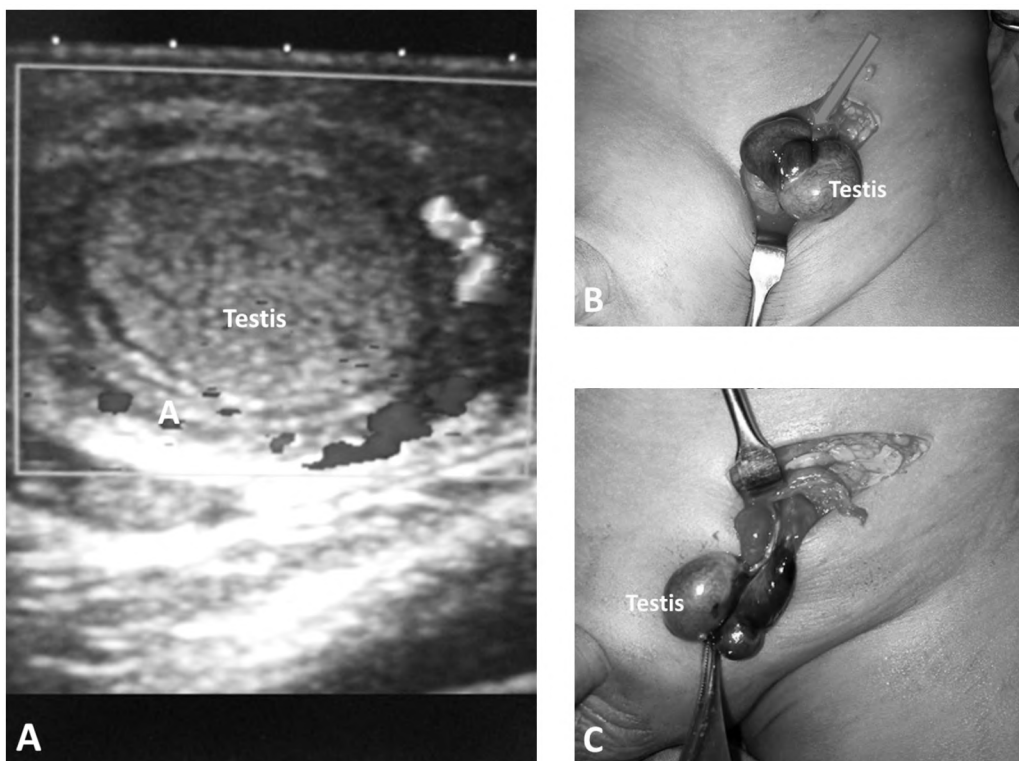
Acute testicular torsion in a boy. (A) Color Doppler image shows the testicle without vascularity. (B) Surgical photo during operation (undescended testis with torsion) shows the site of the torsion (arrow). (C) Viable testis is noted after de-rotation of the torsion.
